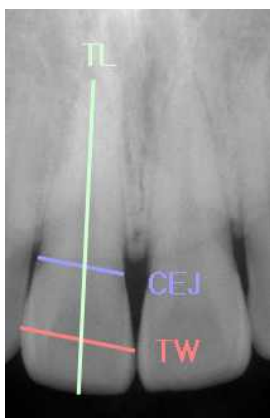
Measured distances of radiographs.
